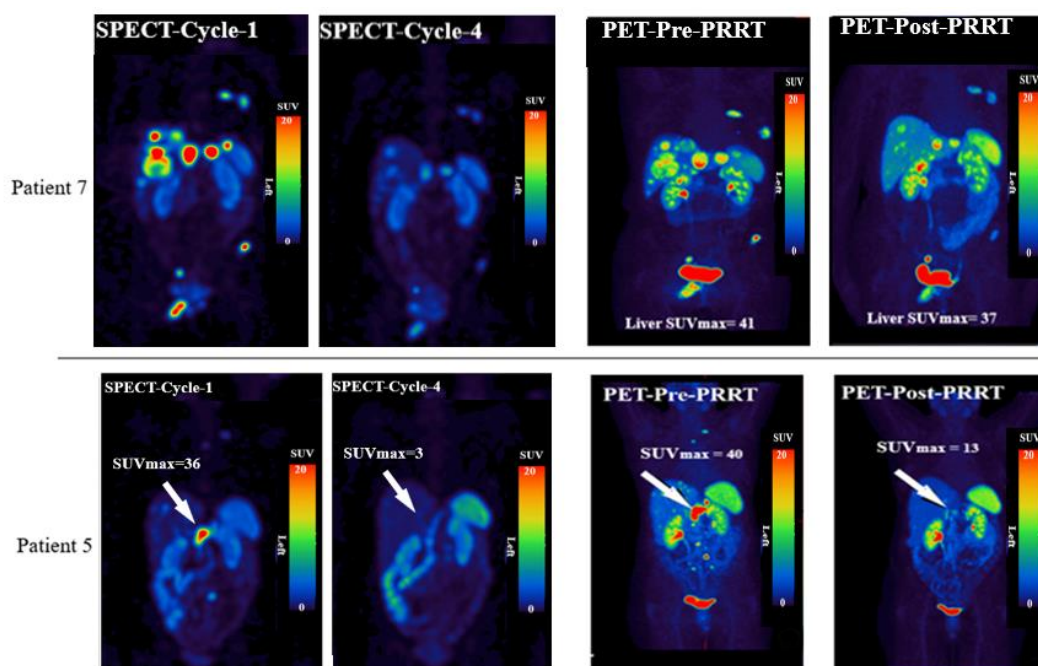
Examples of MRT response in two NET patients Dota7 (top) and Dota5 (bottom) with different disease burden. SPECT/CT at 24-h following PRRT cycles 1 and 4 and PET/CT pre- and post PRRT MIP images showing changes in PET and SPECT-derived SUV are visually correlated. Patient 7 (top) shows partial response in both SPECT and PET as SUV reduced by >70%. Patient 5 (bottom) shows >70% reduction in the mid-abdomen lesion (arrow) in both SPECT and PET.
